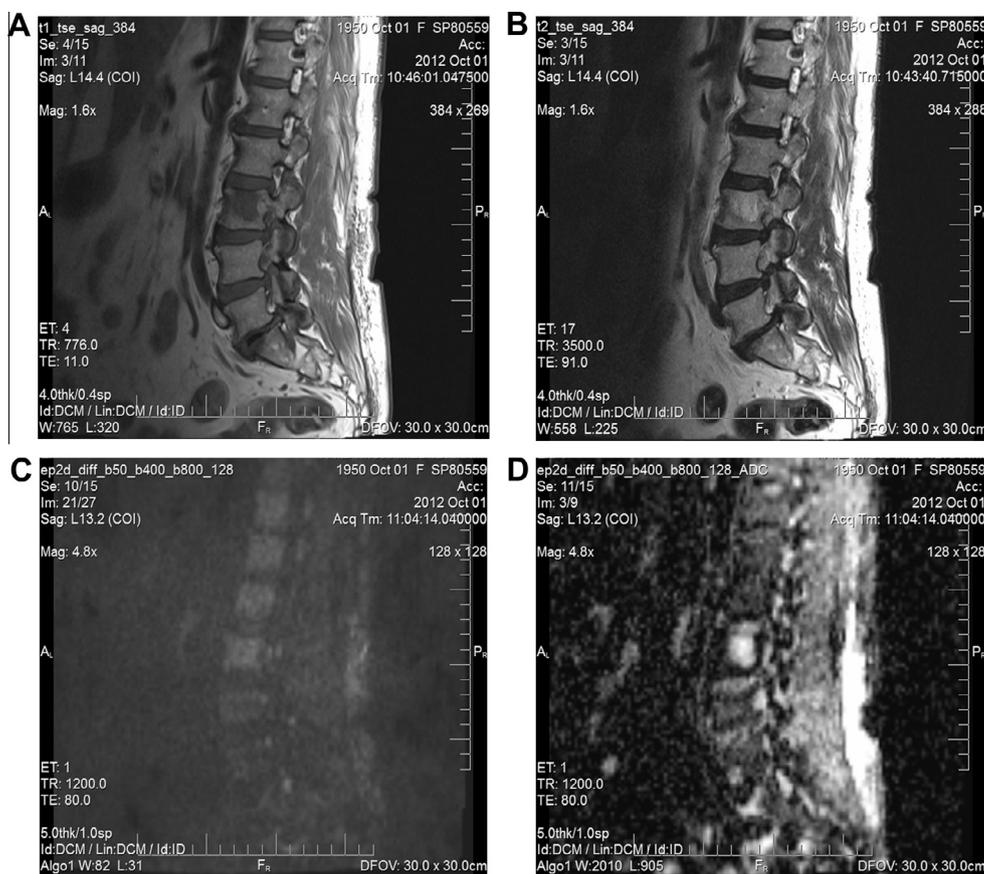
Sagittal T1 (A) and Sagittal T2 (B)weighted images showing focal T1 hypo-intense and T2 hyper-intense lesion at LV3 vertebral body with minimal high signal at DWI (C) and high signal at ADC map (D). The corresponding axial (E), Sagittal (F) and coronal (G) CT images revealed a well defined hypo-dense lesion with internal coarse vertical trabeculae matching with atypical hemangioma.
